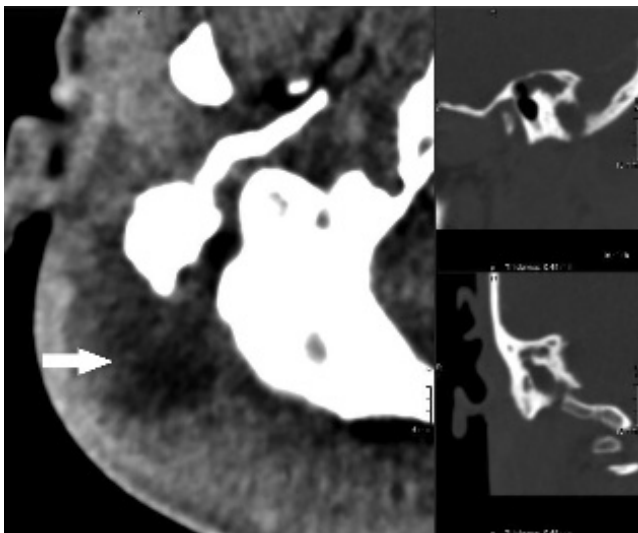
Axial, coronal and sagittal CT images showing right mastoiditis, with loss of internal bony septation, and Bezold abscess below the mastoid tip (arrow).
